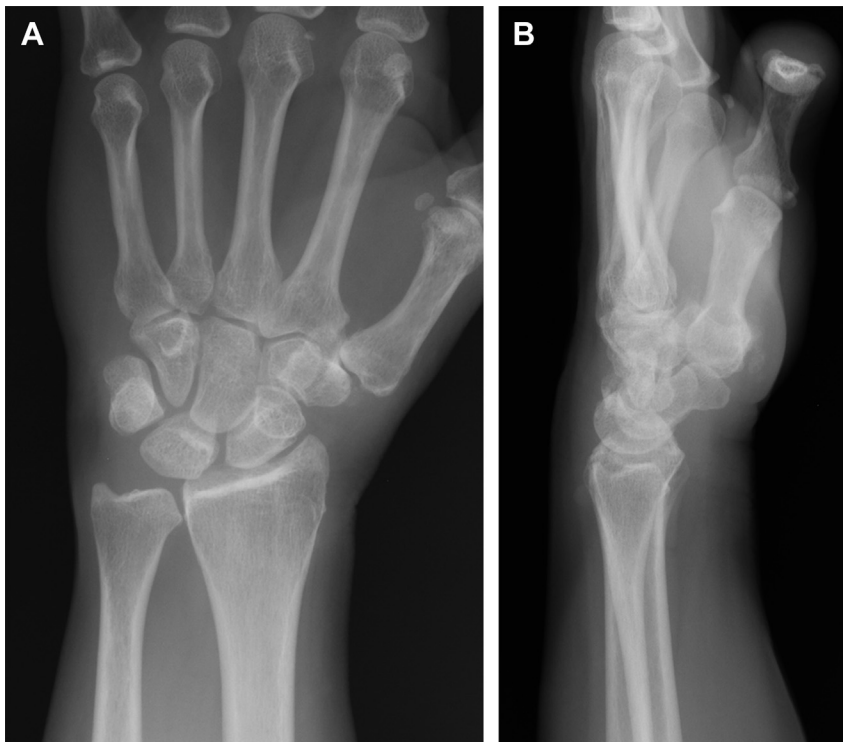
(A) Posteroanterior (PA) and (B) lateral radiograph of a patient with the classic VISI.
